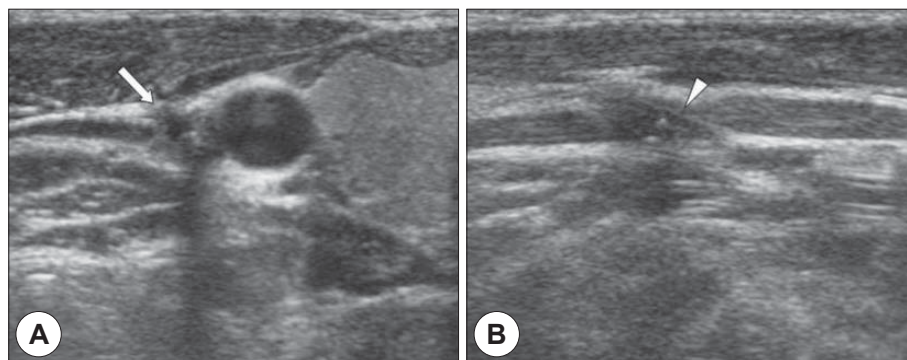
Ultrasonography shows swollen vagus nerve(arrow, A) and catheter which looks penetrating through vagus nerve(arrow head, B).
